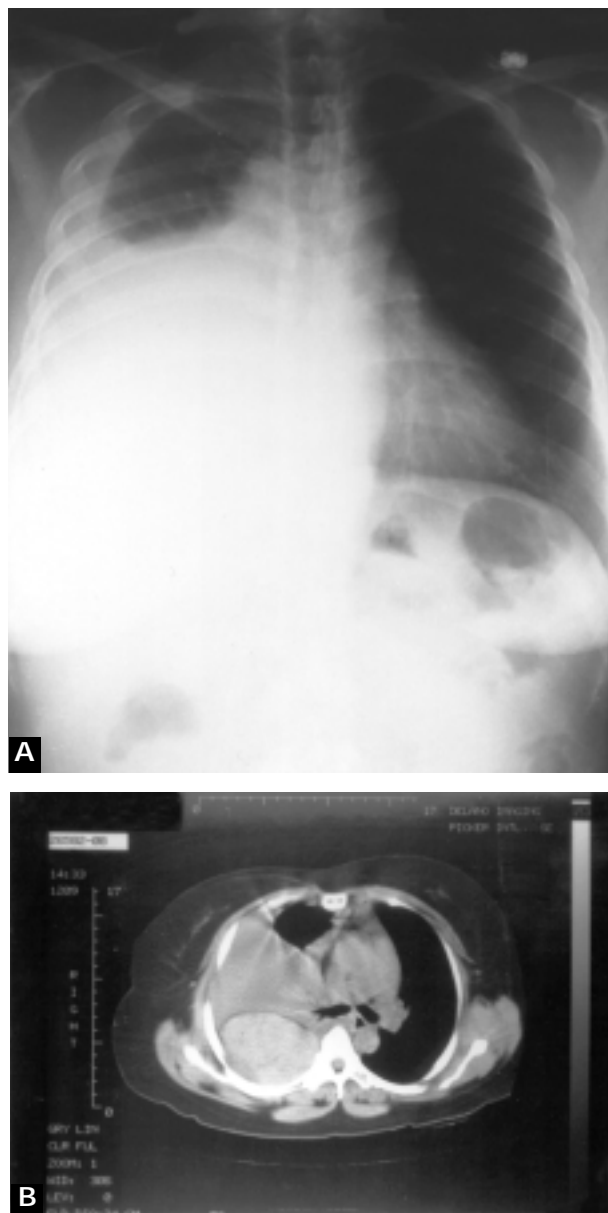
A) Chest radiography and B) computed tomography of a patient with right pleural effusion.
